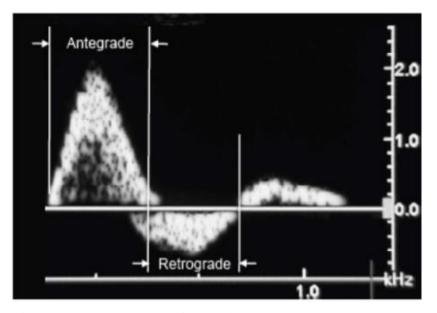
Doppler waveform with antegrade and retrograde velocities identified.
